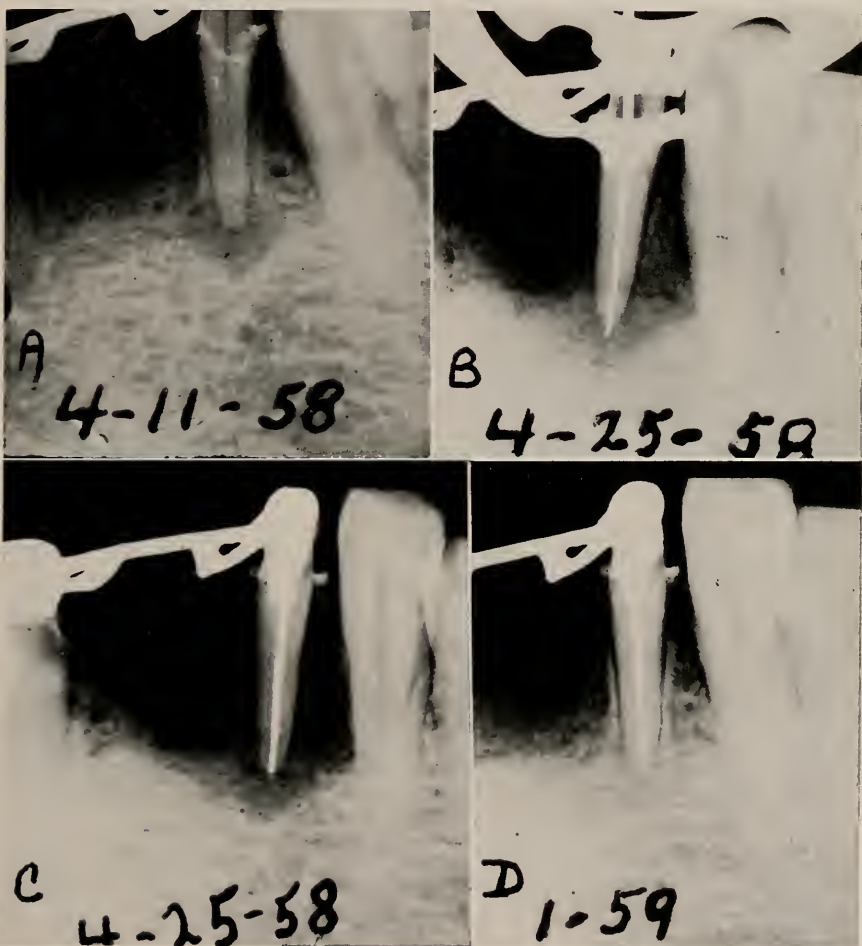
Case 3. Diabetic patient. A. Diagnostic x-ray showing apical rarefaction. B. X-ray showing extensive area of periapical rarefaction two weeks after initial treatment. The canal is sterile and a trial silver cone is evident. C. X-ray directly following root canal filling. D. Nine months following initial treatment showing complete regeneration of bone and lamina dura.
